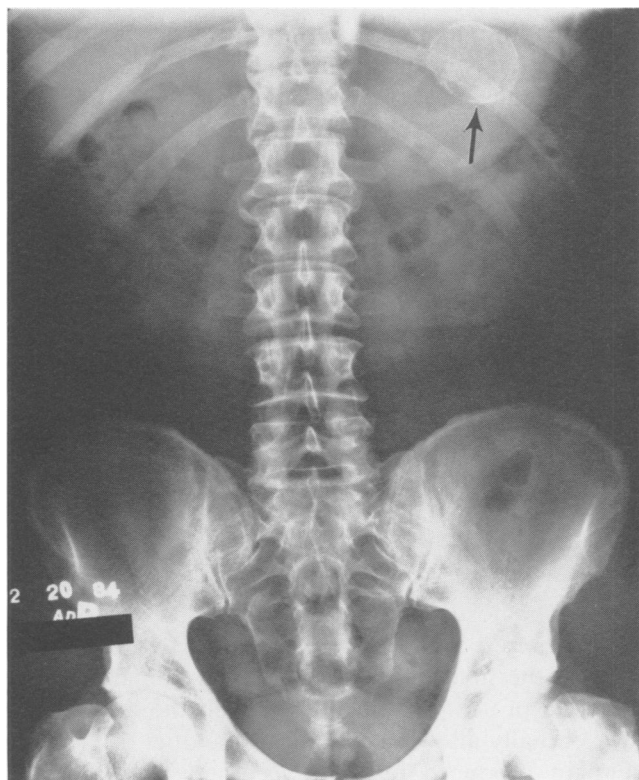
(Case 2). Abdominal radiograph reveals calcified spherical mass (arrow) in left upper quadrant.
